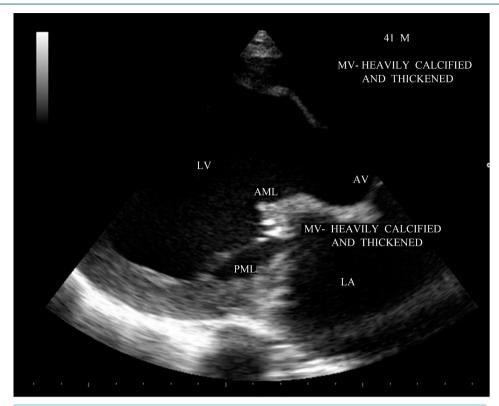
Parasternal long axis view showing the thickened and calcified mitral valve.
